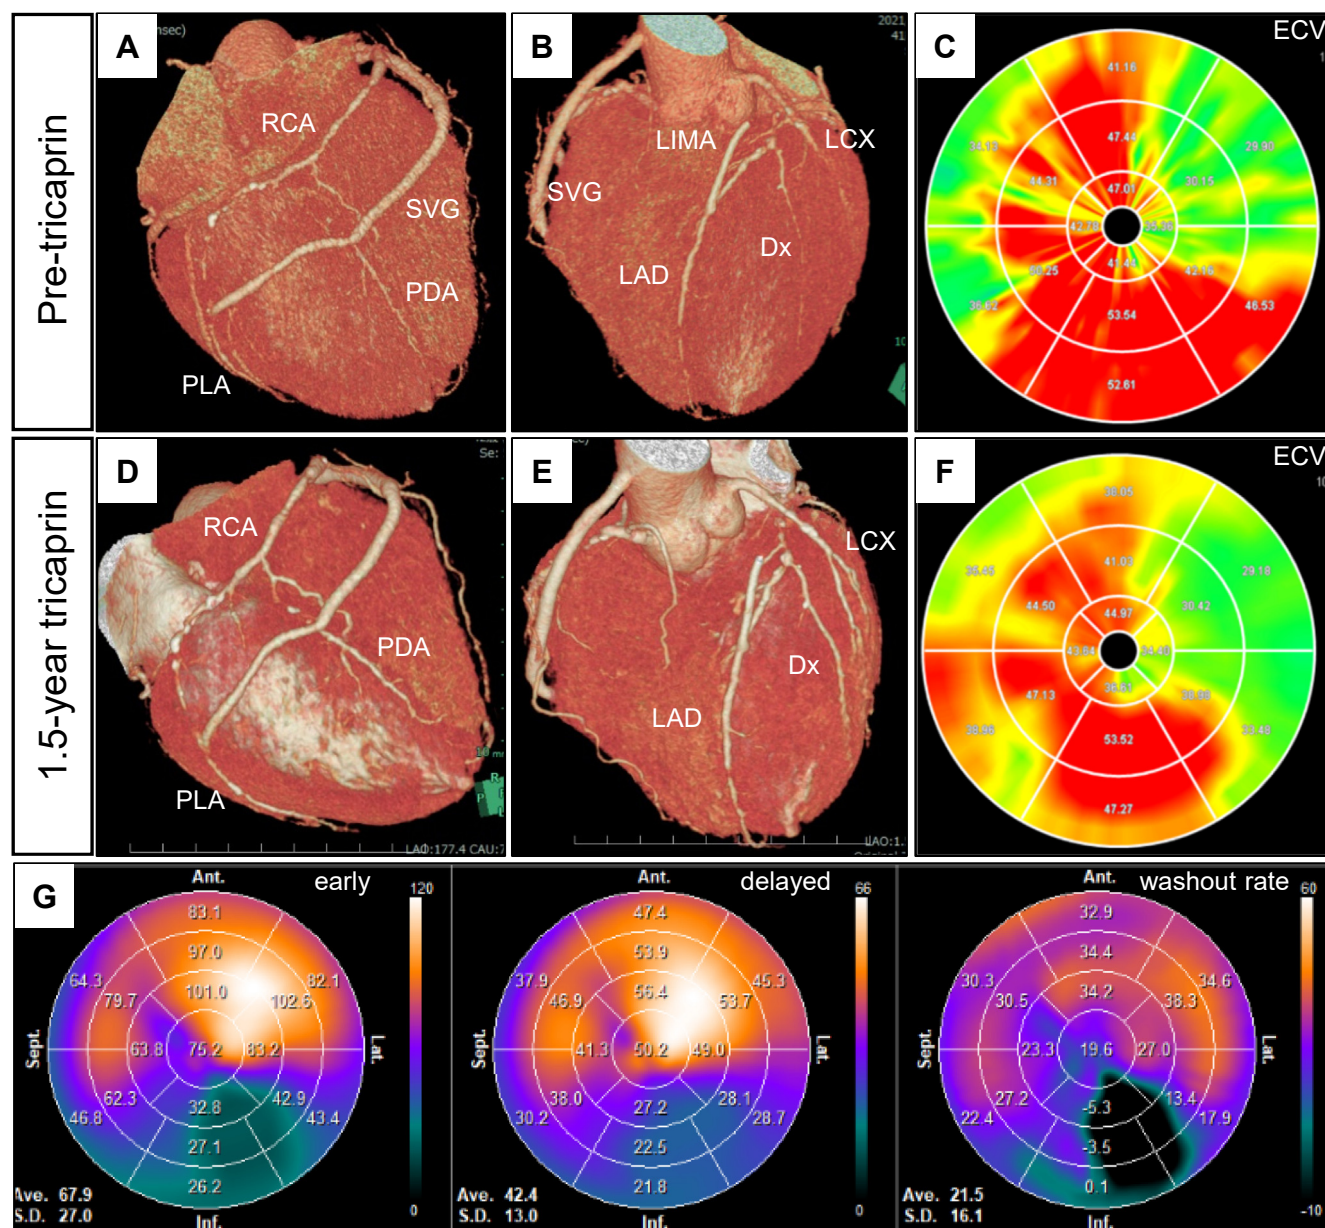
The effects of tricaprins treatment on coronary artery disease and the associated myocardial fibrosis. (A, B, D, E) Volume-rendering reconstructions and (C, F) myocardial extracellular volume (ECV) polar maps. (A, B) Coronary computed tomography angiography (CCTA) confirms the patency of the left internal mammary artery (LIMA) to the left ascending artery (LAD) and the saphenous vein graft (SVG) to the posterior descending artery (PDA) and the posterolateral artery (PLA). Note that the native coronary arteries are diffusely stenosed or partially occluded. (D, E) Post-treatment CCTA reveals the improvement in the atherosclerotic lesions in the native coronary arteries with concurrent luminal dilatation. (C) ECV analysis calculated using late iodine-enhanced cardiac imaging shows that an increase in ECV area, an index of myocardial fibrosis, is observed at baseline and (F) improves considerably at 1.5-years post-treatment (mean ECV: baseline, 41%; post-treatment, 36%). (G) Post-treatment bullseye map of single-photon emission computed tomography image with ^{123}I - β -methyl iodophenyl-pentadecanoic acid reveals a marked improvement in the myocardial washout rate, of 21.5%. Ant., anterior wall; Dx, diagonal; Inf, inferior wall; Lat., lateral wall; LCX, left circumflex artery; RCA, right coronary artery; Sept., septal wall.
